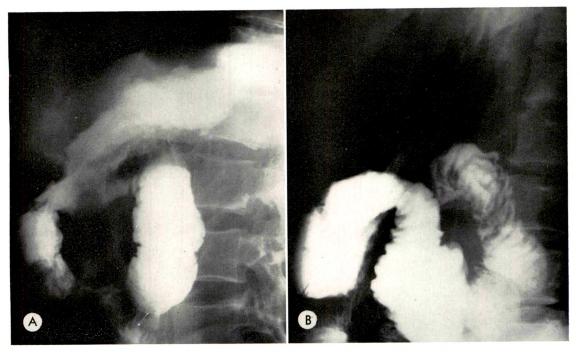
(A and B) Roentgenograms made in right lateral recumbent position are shown from the examinations of 2 patients with acute pancreatitis. The distal stomach is displaced anteriorly from the spine by the enlarged pancreas and the adjacent inflammatory process. The descending duodenum is also displaced anteriorly in B. The diagnosis of acute pancreatitis was made on clinical grounds in A and after surgical exploration in B. In both cases, the roentgenologic diagnosis was acute pancreatitis. See also Figure 2, A and B.
